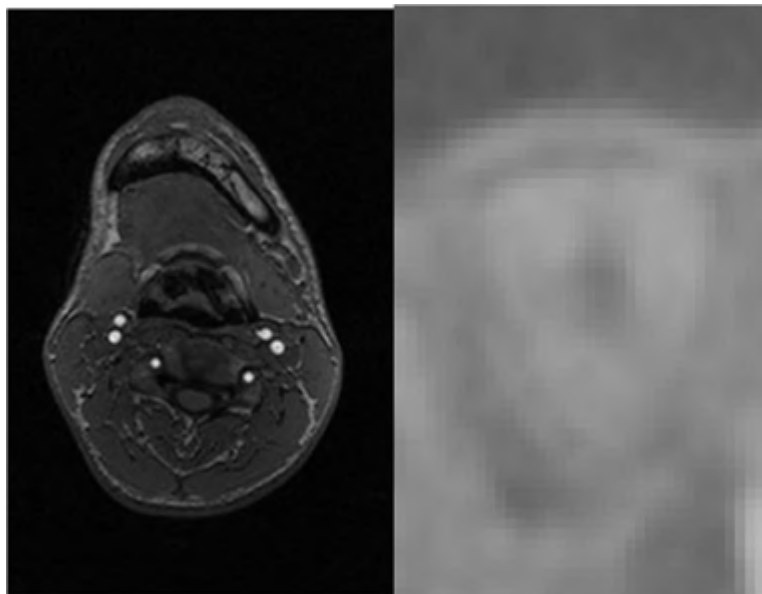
Segmentation difficulties: image inhomogeneity, low contrast and noise (Left image is a human mandibular body on an MRI; right image is a human tooth on a CBCT).
